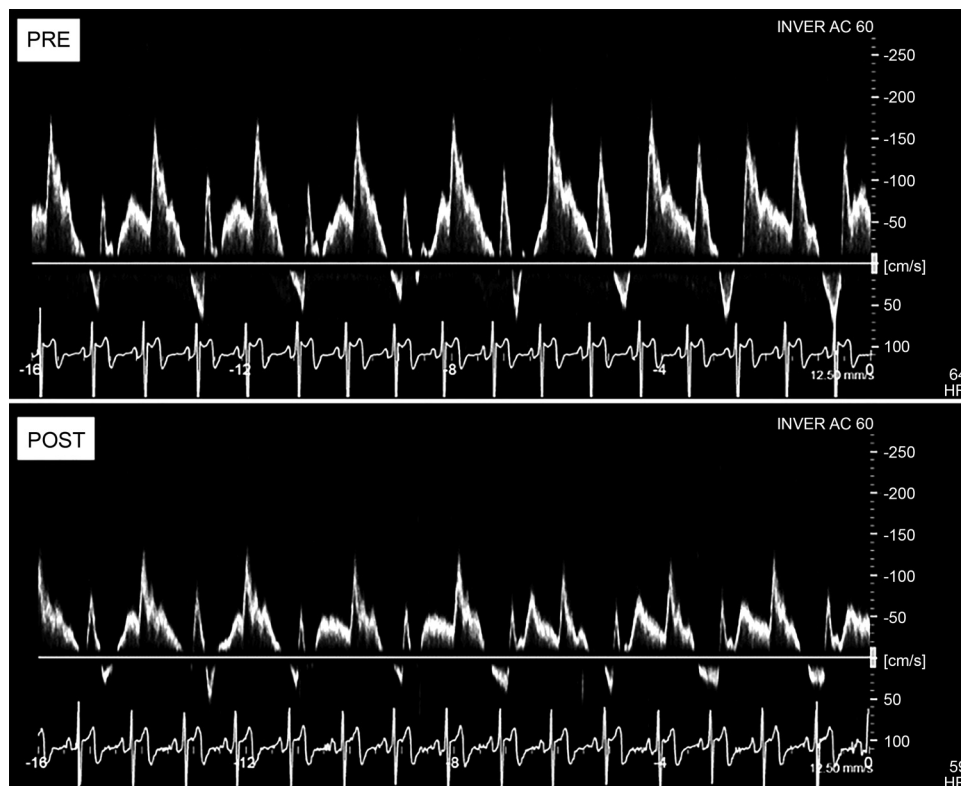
Brachial artery blood velocity dynamics for a representative subject before and after 6 wk of maximal strength training (MST). Shown are two 16-s pulsed wave Doppler recordings during steady-state dynamic handgrip exercise corresponding to 60% of pretest maximal work rate ( $WR_{max}$ ).
